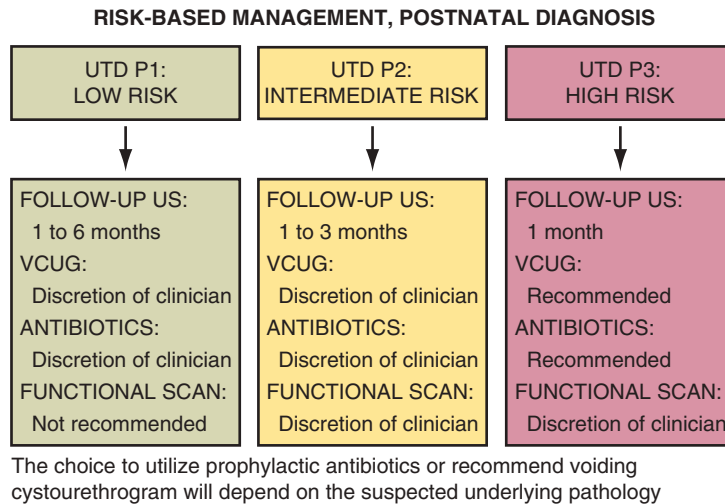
Risk-based management for urinary tract dilation (UTD) that persists into the postnatal period. US, ultrasound; VCUG, voiding cystourethrogram. (Adapted from Nguyen HT, Benson C, Bromley B, et al: Multidisciplinary consensus on the classification of prenatal and postnatal urinary tract dilation [UTD classification system]. *J Pediatr Urol* 10(6):982-998, 2014.)
